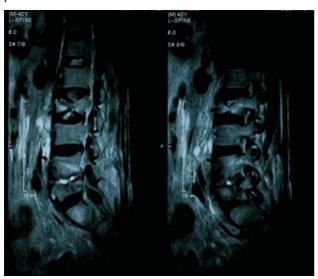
MRI of the lumbo-sacral spine showing collapse of D12, L2, L4, and L5 vertebral bodies.
